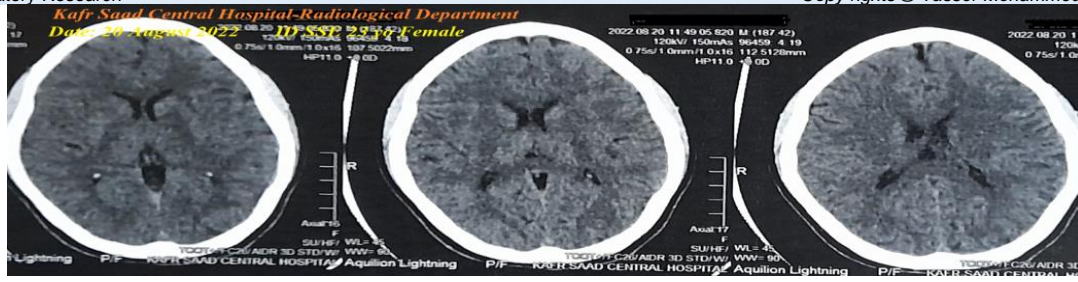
There is laboratory hypocalcemia. Brain CT was normal
